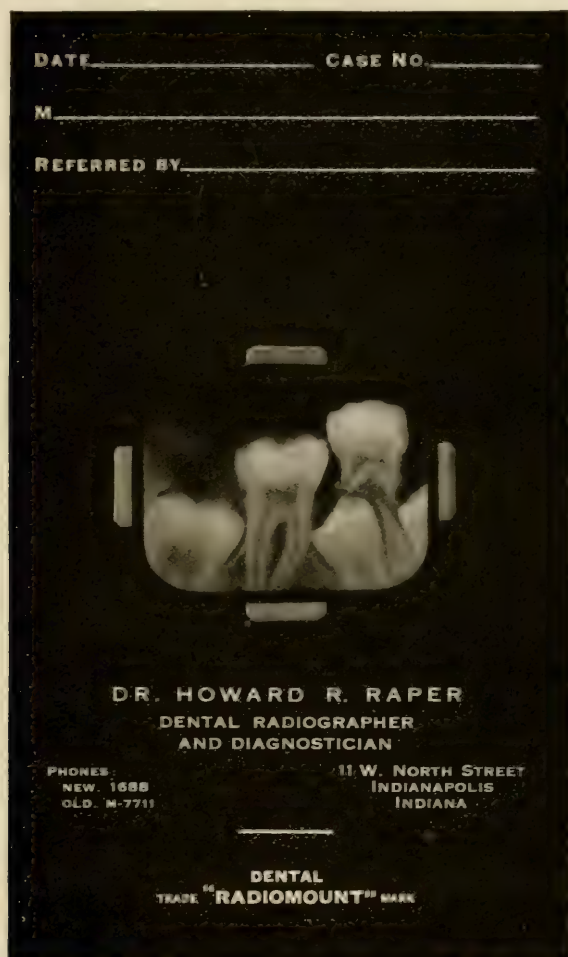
Radiomount to hold dental X-ray negatives.
